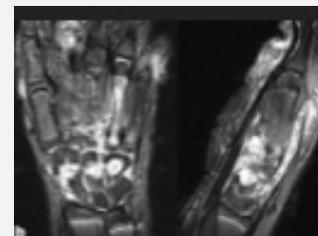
MRI sagittal and coronal views.
